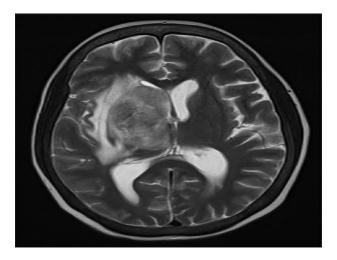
MRI picture showing right gangliocapsular infact.
